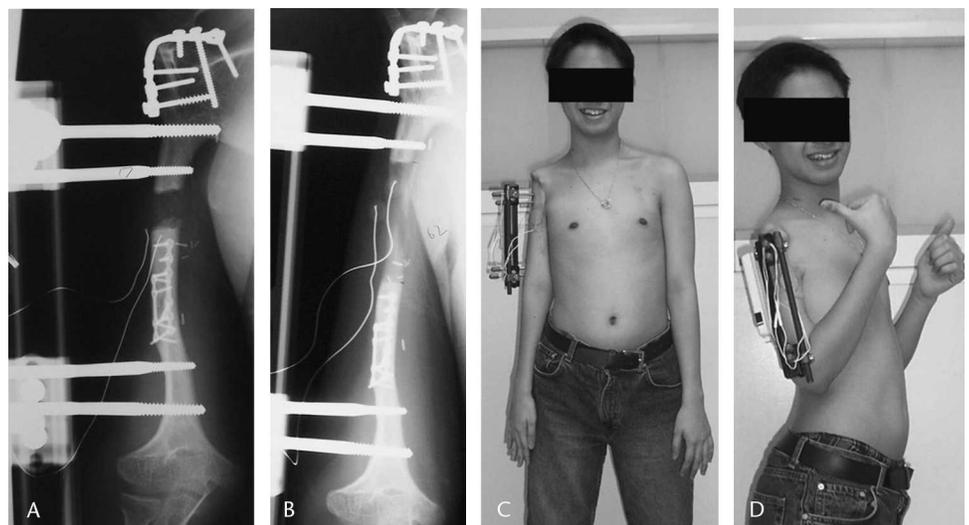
Radiographs show the patient’s (A) right humerus at 1 month and (B) at 3 months of distraction. Photographs show the patient during (C) the distraction phase with improved LLD and (D) the patient’s elbow flexion during the distraction phase.
